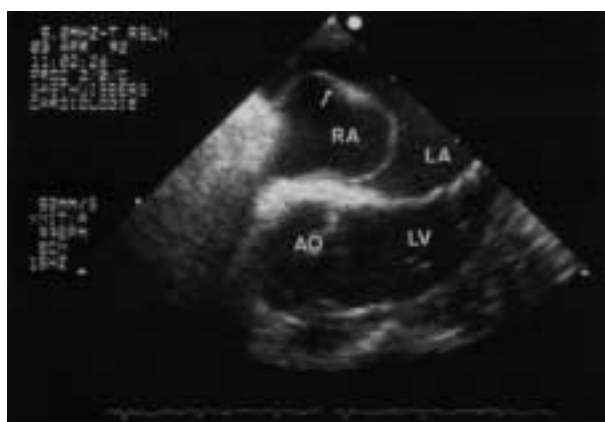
Transoesophageal echocardiographic view showing the cavities of the left atrium, (LA) left ventricle, (LV) right atrium, (RA) and aorta, (Ao). An aneurysm of the interatrial septum is bulging into the left atrium (arrow).
